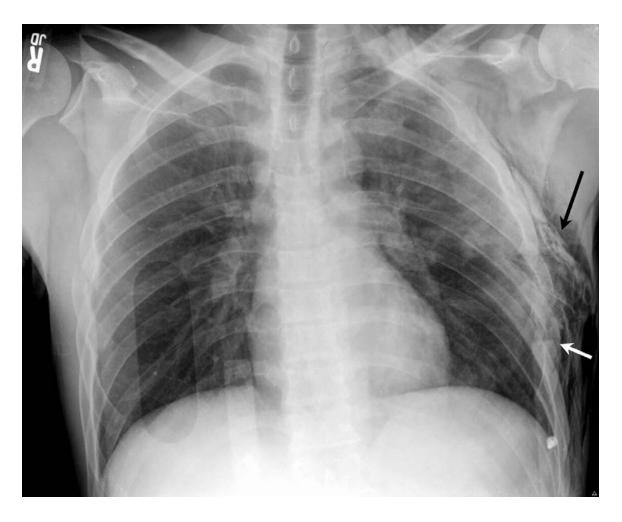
Rib Fracture in a x-ray
